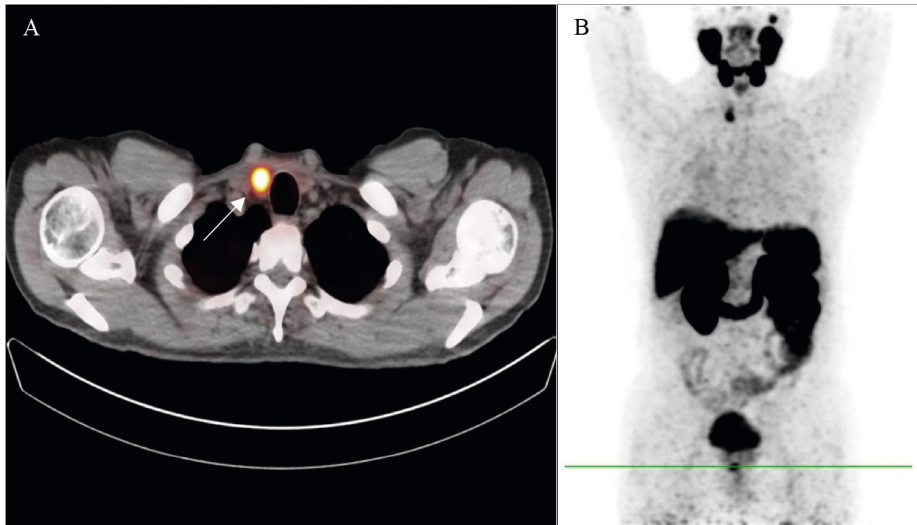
Focal thyroid PSMA uptake on the right side on A) ^{68}Ga -PSMA PET/CT fused image and B) ^{68}Ga -PSMA PET/CT maximum intensity projection (MIP) image.
